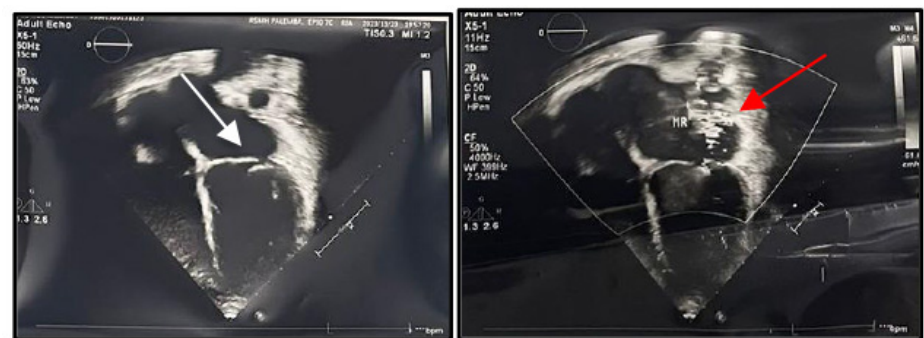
Echocardiography showed anterior mitral valve tear (white arrow) and mitral regurgitation (black arrow)
